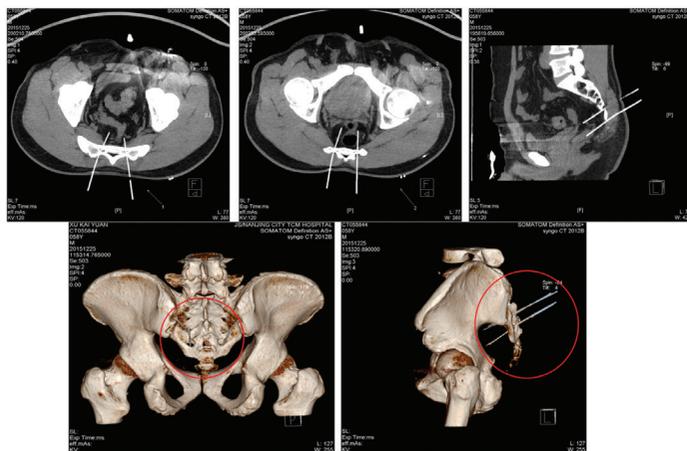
The needle position confirmed into the anterior sacral foramen in 3D-CT image, cross-section and sagittal view
